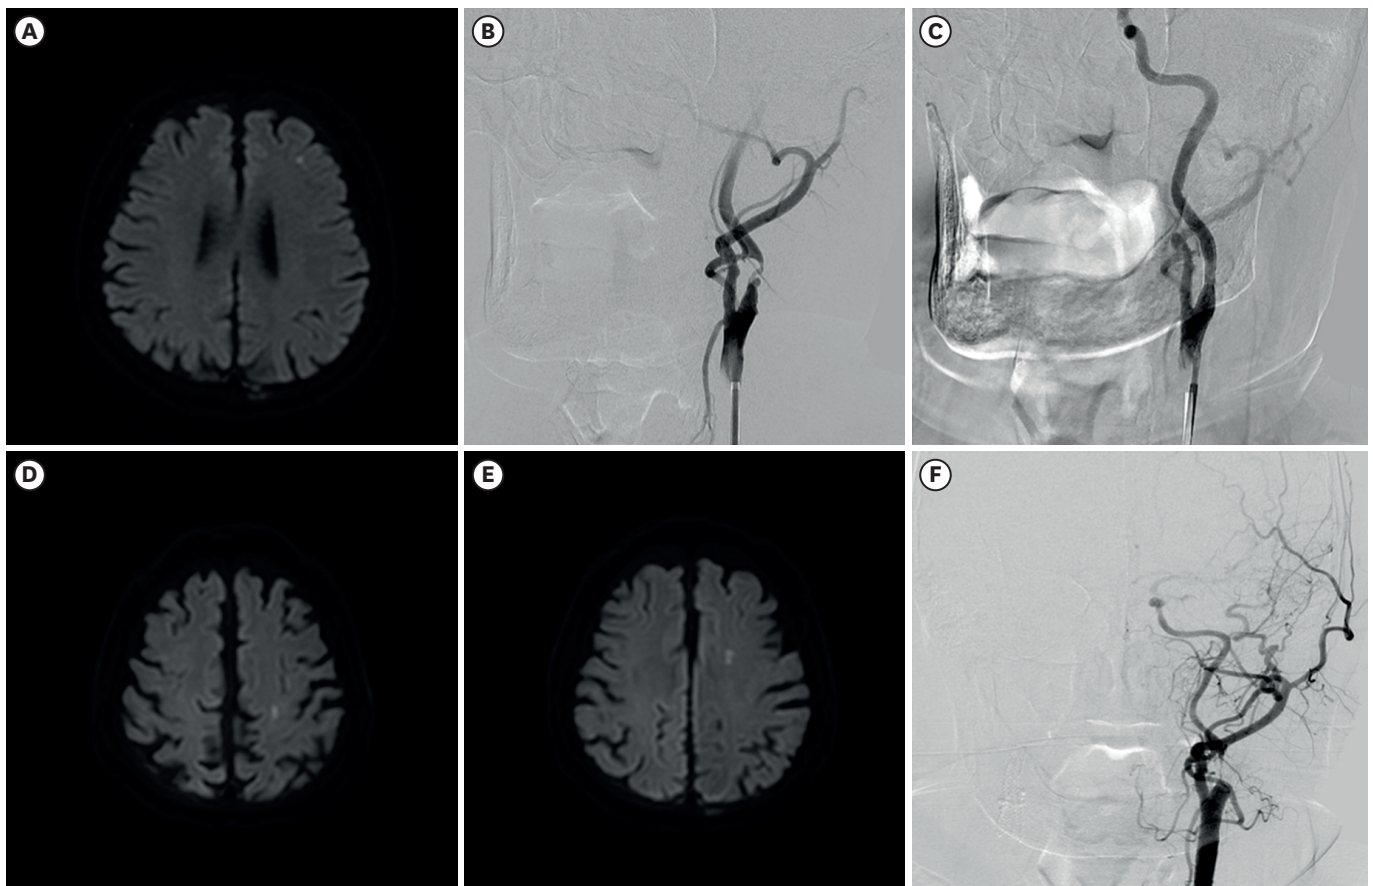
Representative case of stented-territory infarction associated in-stent restenosis. Initial DWI demonstrates acute ischemic stroke on the left frontal cortex (A). Initial conventional cerebral angiography shows severe stenosis on the left proximal ICA (B). After CAS, left carotid angiography shows improved ICA flow (C). Two years after CAS, DWI for dysarthria reveals newly developed stented-territory infarctions on the left frontal lobe (D-E). Follow-up cerebral angiography demonstrates in-stent restenosis on the left proximal ICA (F).
